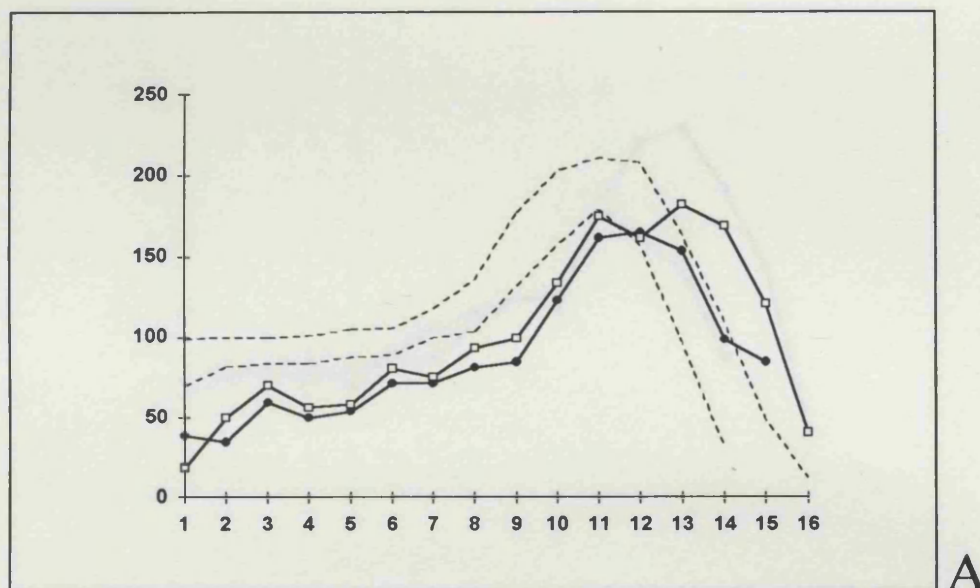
Diffuse HS on the right in combination with posterior atrophy of the left hippocampus. Patient was a 41 year old man, with a history of prolonged FC lasting more than four hours following measles vaccination at the age of 1 year. He had intractable TLE with CPS and secondary generalization. Interictal EEG showed generalized spike wave discharges and a right temporal lobe focus. On the hard copies of the standard MRI scan, the hippocampi appeared more or less symmetric, with a bright signal on the right. On closer examination of the MPRAGE however, the right hippocampus was smaller on all sections, and markedly so at the level of the head (white arrows on section 14 in C). Notice also the hypodense signal in the right hippocampus on the MPRAGE in section 9 and 14, consistent with a diagnosis of HS. Inspection of the HCV distribution graph (A) showed diffuse atrophy of the right hippocampus and in addition posterior atrophy of the left hippocampus compared to the control graph (black arrow on section 9 in C). $HCV(R/L) = 0.80$ ($NI \geq 0.87$); $HCV \text{ right} = 3938 \text{ mm}^3$, $HCV \text{ left} = 4877 \text{ mm}^3$ ($NI: \geq 4348 \text{ mm}^3$); $HCT2 \text{ right} = 130 \text{ msec}$ (white arrow on HCT2 map), $HCT2 \text{ left} = 102 \text{ msec}$ ($NI \leq 108 \text{ msec}$). On the HCV distribution graph, the black circles represent the right hippocampus and the open squares the left hippocampus. [Hospital number: QSC23479].
